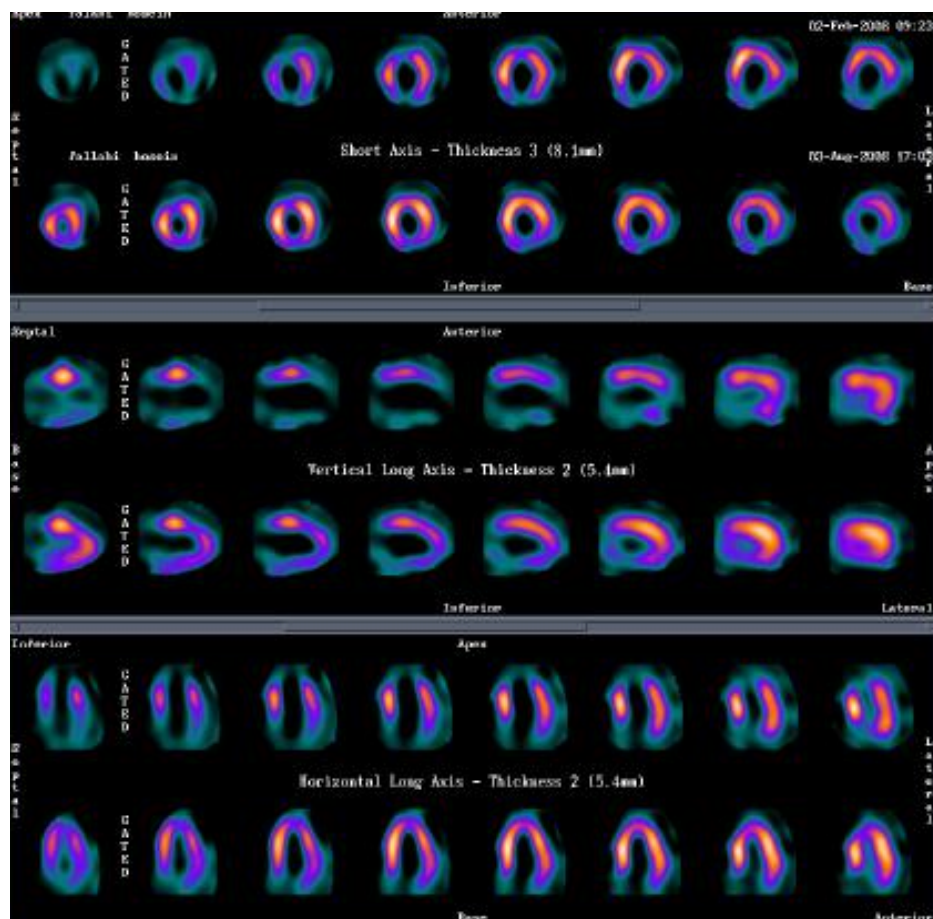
Myocardial perfusion of most anterior segments of heart by single photon emission computed tomography (SPECT) pre and post laser
